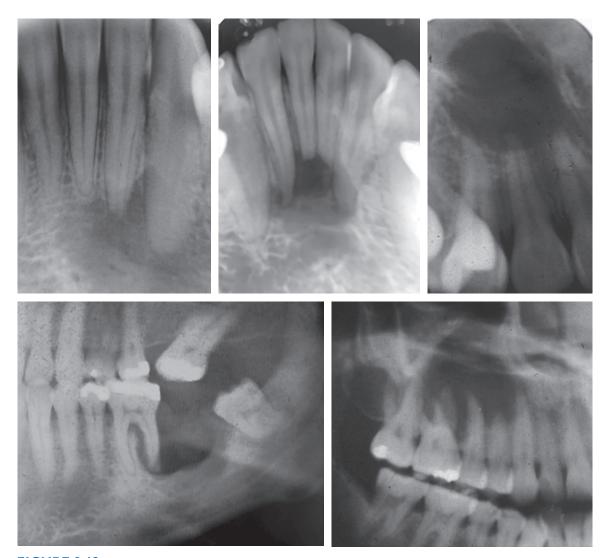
Central giant cell granuloma appearing as periapical radiolucencies with root resorption.
